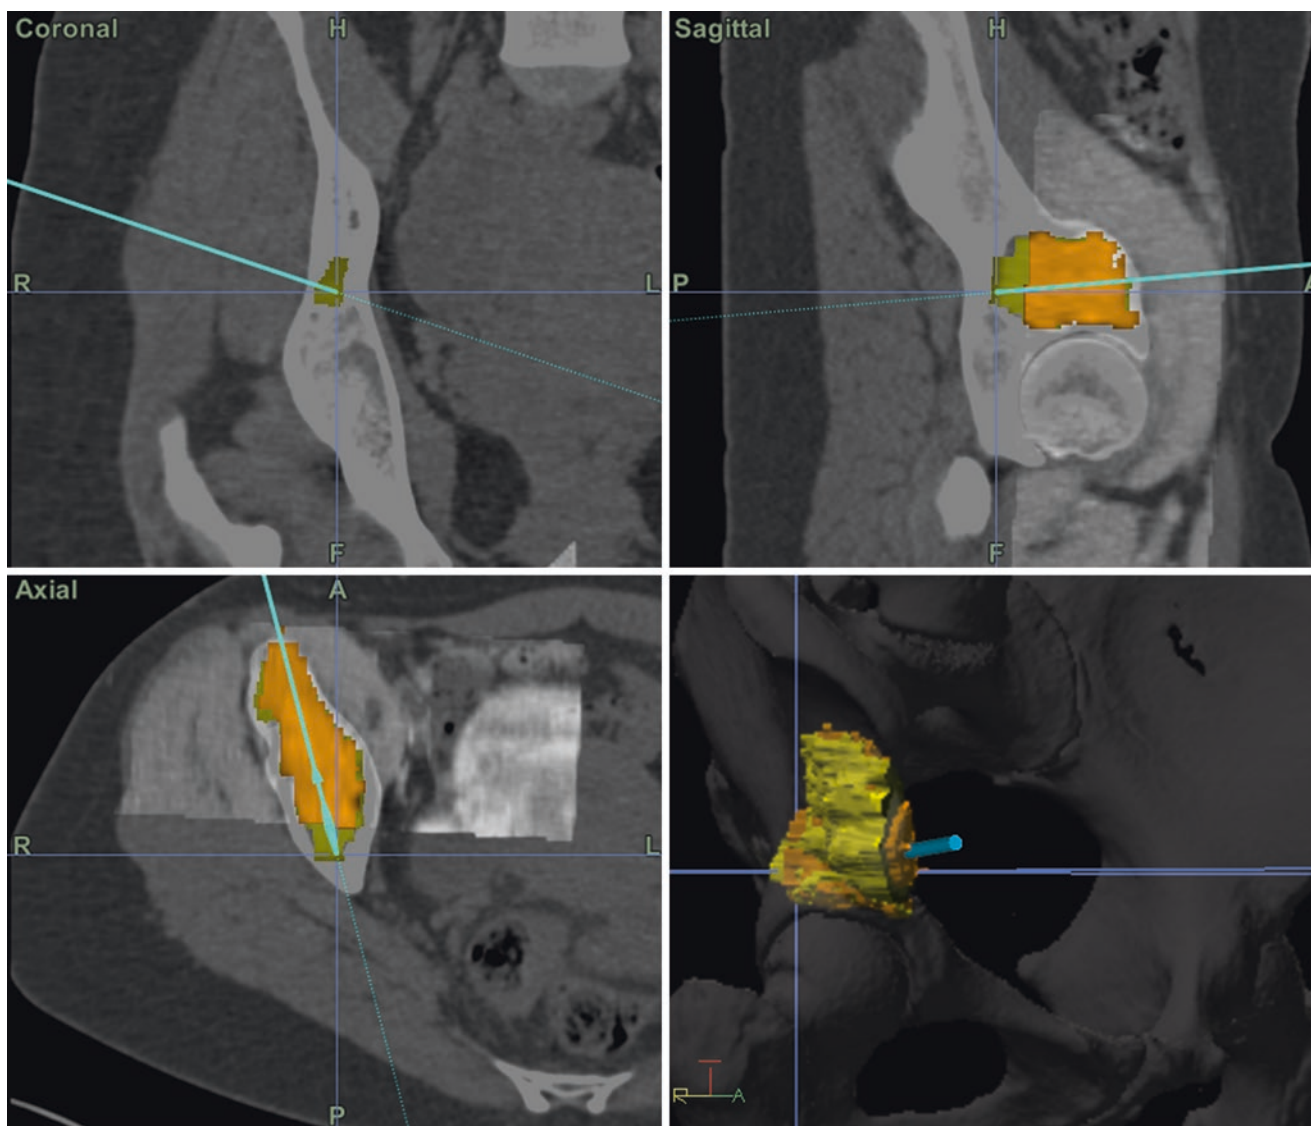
View of the navigated curette inside the segmented tumour. The image is composed of a fusion of a CT and MRI scans. The tumour is segmented on both scans (orange and yellow)
